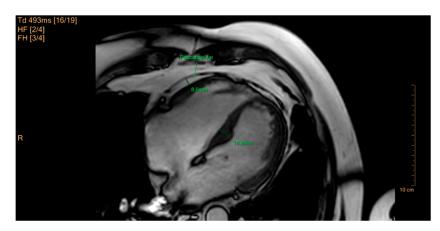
Cardiac MRI, BTFE sequence, cine four chamber view, 8 mm, telediastolic measurement of interventricular septum exhibiting hypertrophy (14.9 mm), epicardial fat thickness of 8 mm lateral of the right ventricle. Prepared by the authors. Courtesy of the Pediatric Clinical Hospital Sibiu, Lucian Blaga University of Sibiu.
